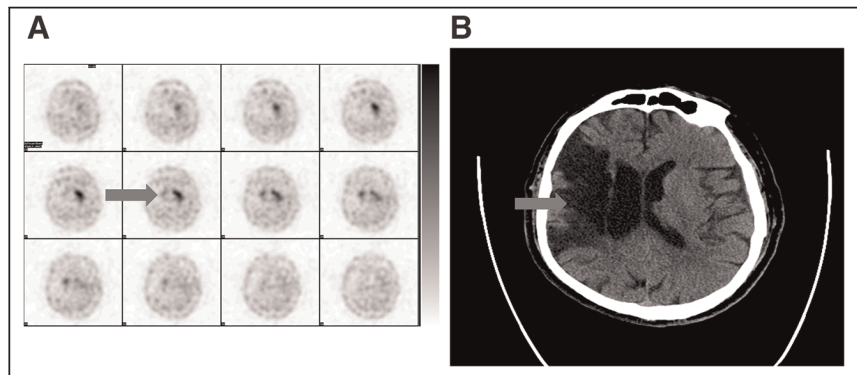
Images of 61-y-old man who had history of infarct in territory of right middle cerebral artery and was being evaluated for right-upper-extremity tremors of 2- to 4-mo duration. (Left) Axial brain SPECT image showing decreased to absent uptake (arrow) in right caudate nucleus and putamen because of prior infarct. (Right) Unenhanced axial CT scan of head showing infarct (arrow).
